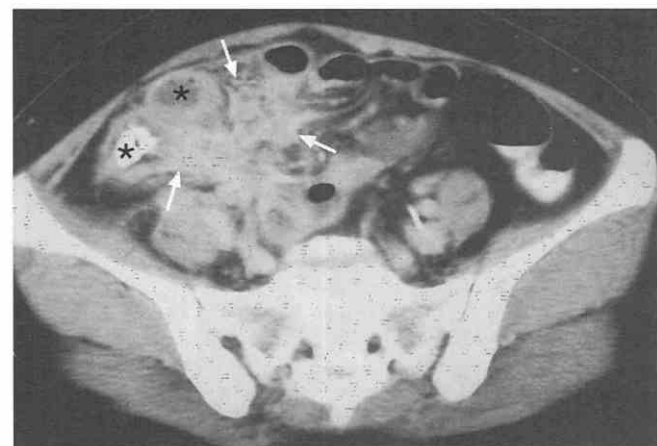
Actinomycosis infection involving the gastrointestinal tract. CT scan shows ill-defined soft tissue lesion (arrows) occupying the right lower abdomen as well as evidence of bowel wall thickening of the distal ileum (asterisks) and diffuse infiltration in the regional fat plane. (From Lee JJ, Ha HK, Park CM, et al: CT features of abdominopelvic actinomycosis involving the gastrointestinal tract. *Radiology* 220:76-80, 2001.)
